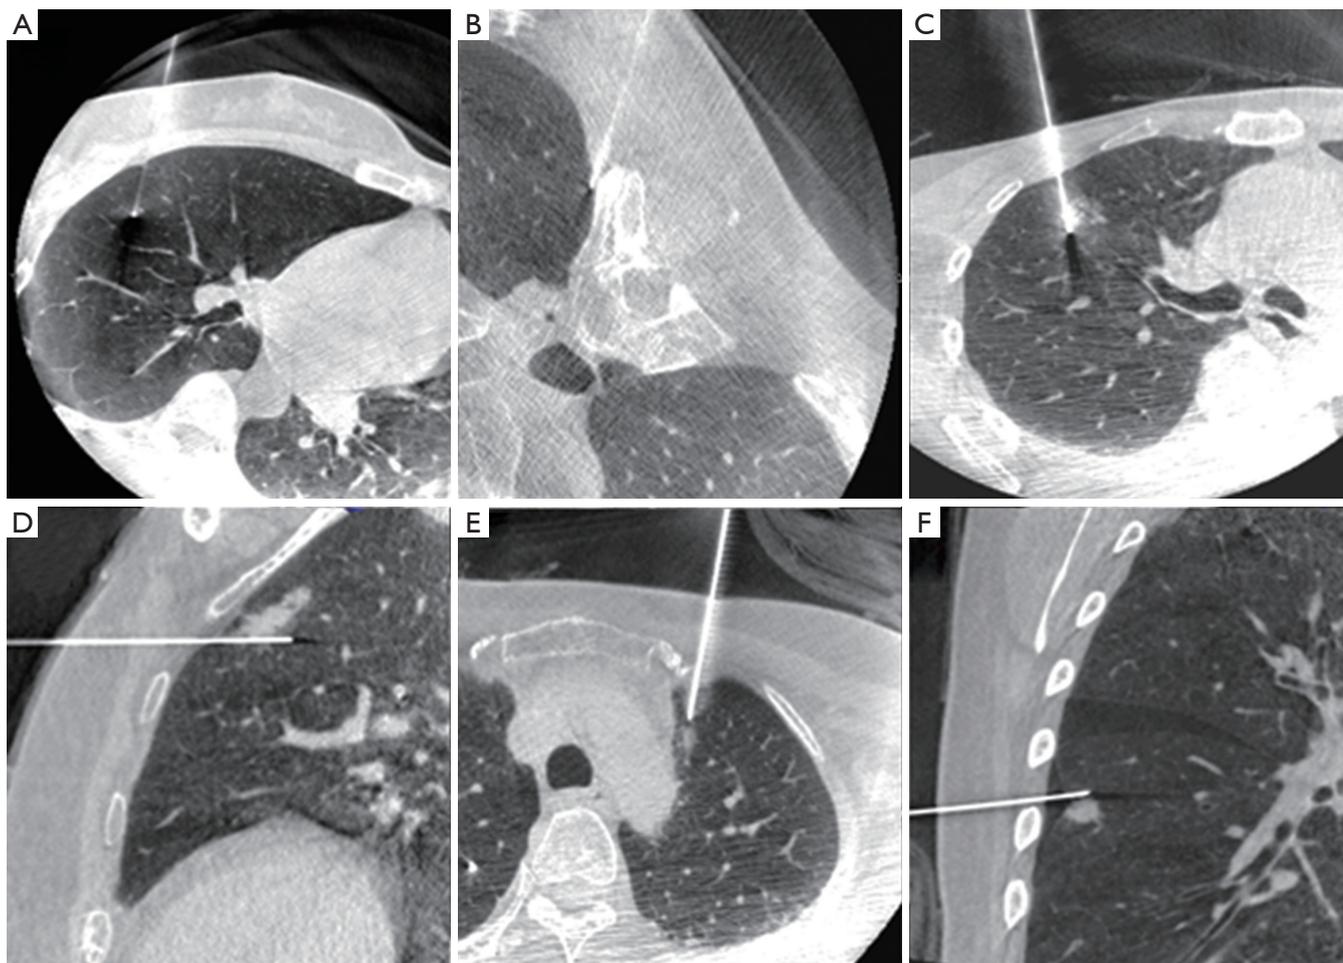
Series needle procedure under C-arm CT guidance. (A) A 6 mm small ground glass opacity in the right lower lung lobe; (B) one small metastatic lesion located in the left upper lobe near the spine; (C) a right upper lobe lung lesion approached from the supine position; (D) localization planning using sagittal CT image; (E) one small left upper lobe lesion near the aortic arch is localized successfully using C-arm CT; (F) small pneumothorax detected during the needle localization procedure.
